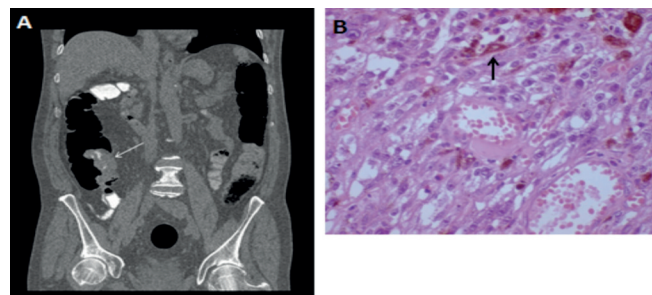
(A) CT colon image representing an irregular 6cm ileocaecal mass (arrow) and (B) High power view (40x) showing tumour cells (arrow) with vesicular nuclei, prominent nucleoli, nuclear pleomorphism and pigment deposition arranged in cords surrounded by fibrous stroma.
